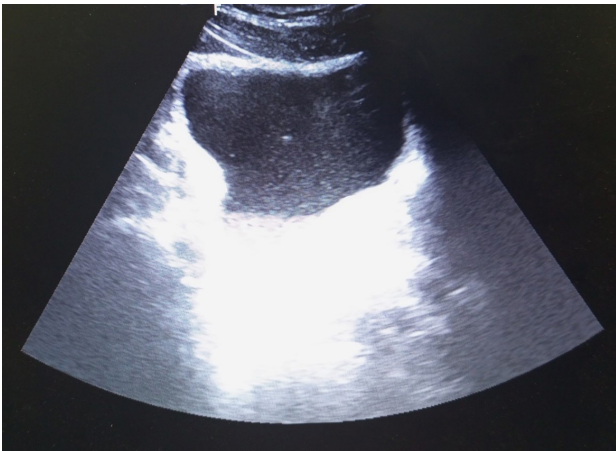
Static grey scale sonogram showing the urinary bladder s containing multiple echogenic specks within the urine.
